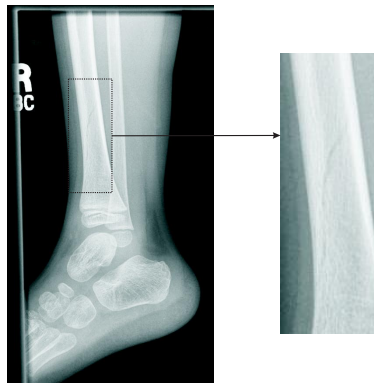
Non-displaced hairline fracture from the leg of an infant, which is often invisible on initial radiographs. If this type of image was transmitted from a hospital to a mobile hand-held device there would be an immediate need to evaluate image quality as a result of the possible loss of image transform coefficients in the ROI or unexpected levels of compression that might degrade feature content in this region.
